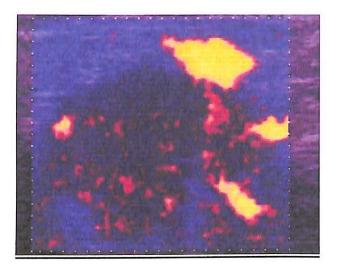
Power Doppler US image showing low flow vessel
